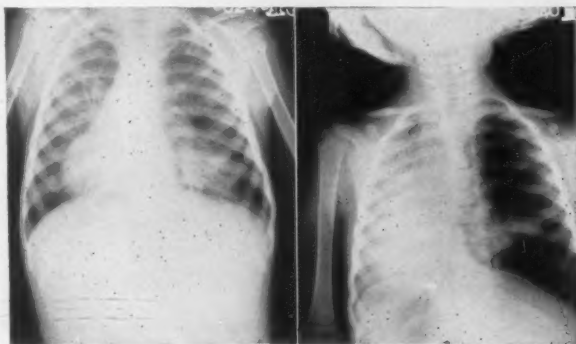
(A) Roentgenogram of the chest of an infant, aged 30 months. On admission both hilus areas show rather marked enlargement. Both bases show a rather marked parenchymal infiltration; (B) Roentgenogram of the same chest just previous to bronchoscopy. Marked shifting of the heart to the left side, due to the marked emphysema of the right lung.
